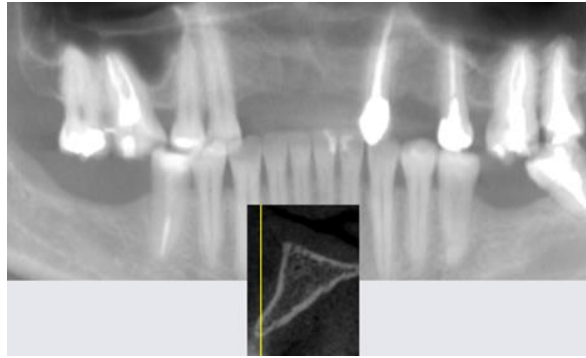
Computed tomography showed the presence of 3mm of remaining bone thickness, with medullary bone, and preservation of alveolar bone height.
